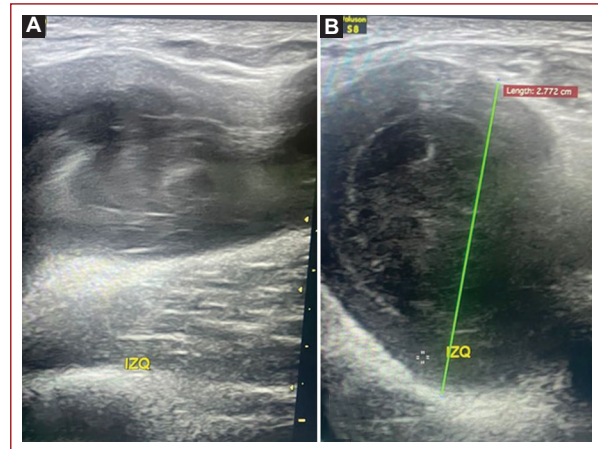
Left pelvic limb ultrasound in a patient in supine position with focus on the lesion, where A: in a longitudinal view, the fusiform dilatation of the aneurysm can be observed, proximal to said aneurysm the common femoral vein is intact. B: in the transversal view, the aneurysm and its length of 2.77 cm in its longest axis.
